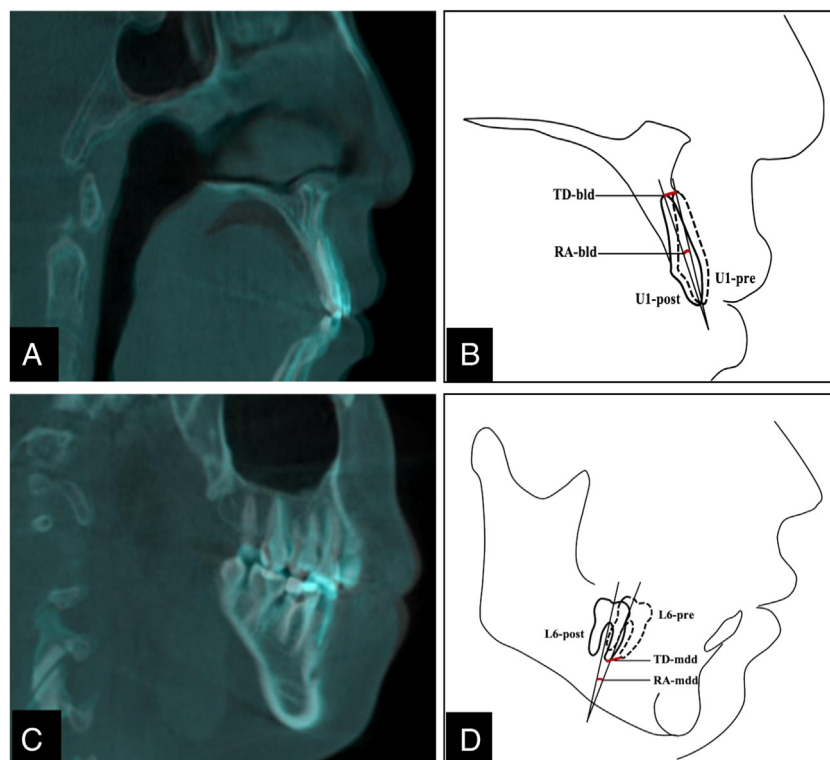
Measurements from the InVivo 5.2.4 software. (A and C) Superimposition of pre- and post-orthodontic CBCT. (B) Measurements of the tooth movement in buccal-lingual direction (bdd). TD (traction distance), distance between pre- and post-orthodontic anatomic root apex; RA (rotation angle), angle between pre- and post-orthodontic long axis. (D) Measurements of the tooth movement in mesial-distal direction (mdd).
